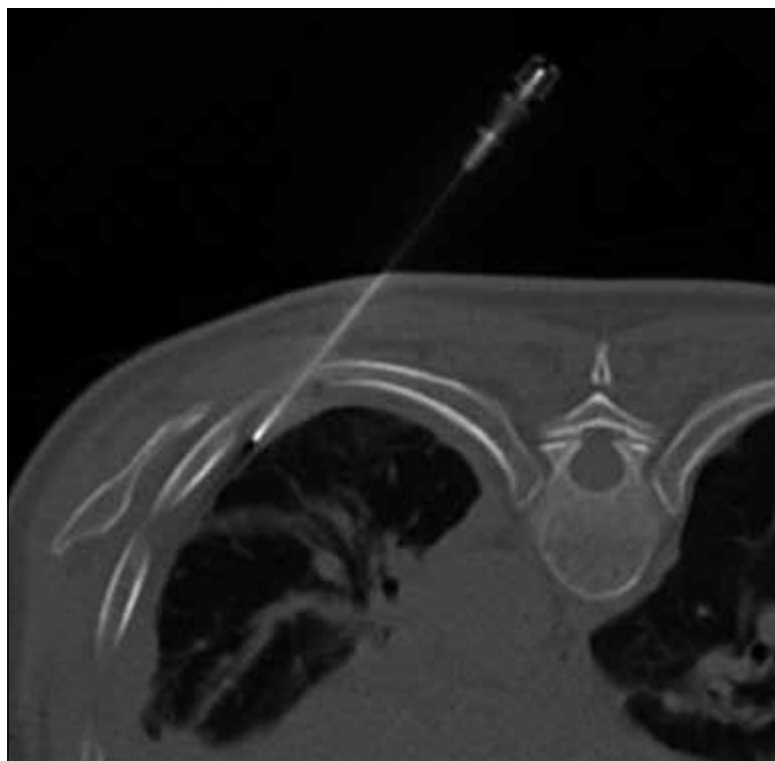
Axial prone computed tomography showing a co-axial 18G core biopsy introducer in situ for targeted pleural biopsy.
